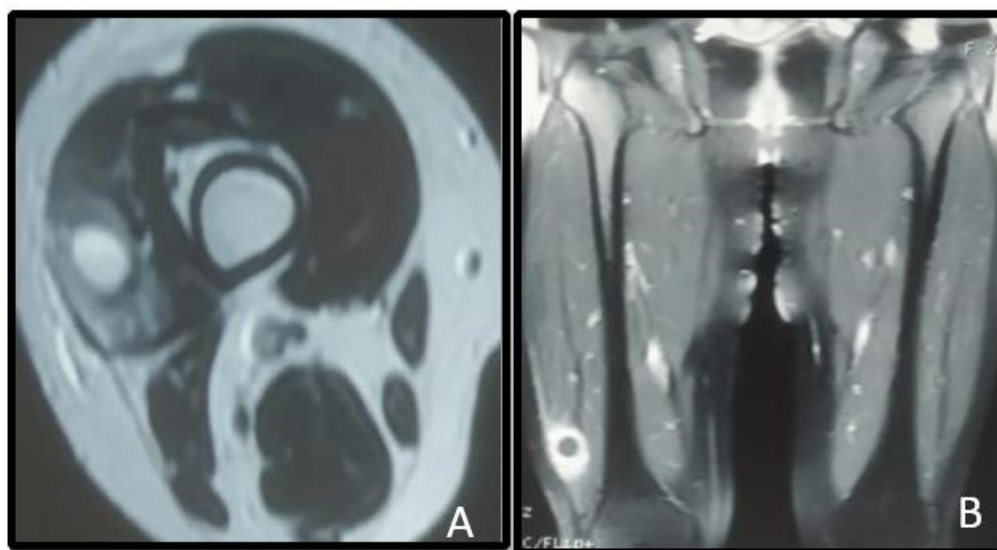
(A, B) MRI - Cystic intensity lesion with peripheral enhancement and surrounding inflammation right lower thigh involving vastus lateralis
